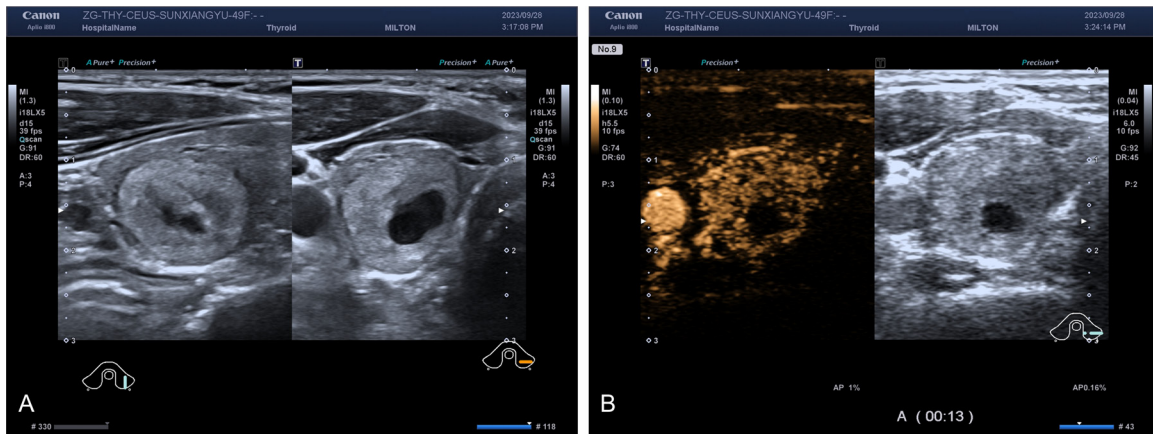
Conventional ultrasound and contrast imaging before ablation in the two groups. A: Conventional ultrasound image of the thyroid before ablation; B: Ultrasound imaging of thyroid gland before ablation.
